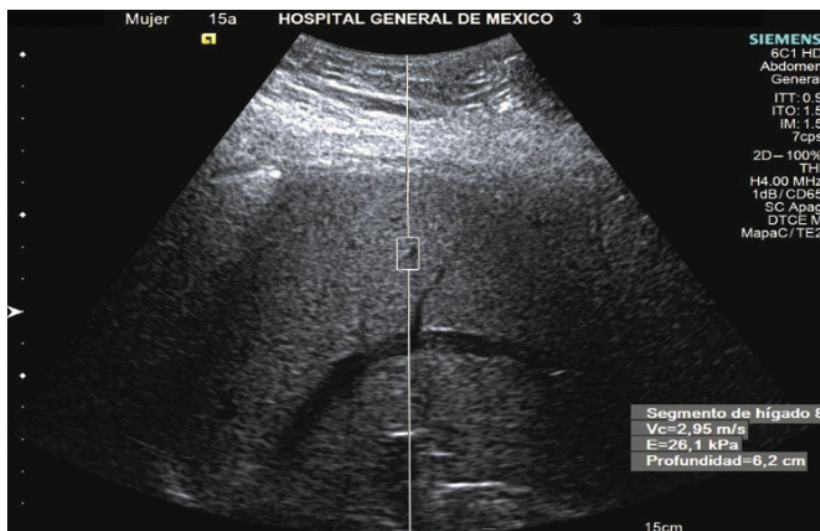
Ultrasound elastography example.
